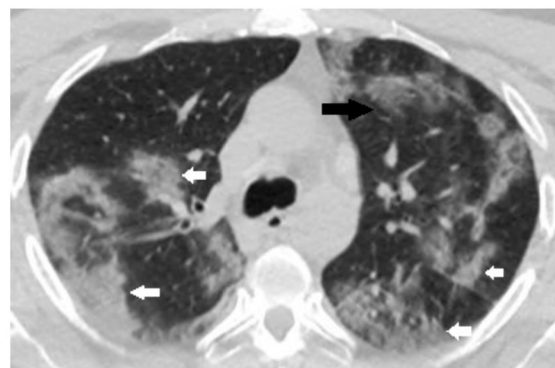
Axial CT image obtained without intravenous contrast material in a 55-year-old man imaged 10 days from symptom onset (late phase) with CORADS 5, shows bilateral consolidative opacities (white arrows), and GGO (black arrow) with a peripheral and central distribution of the lesions and multilobar affection.
